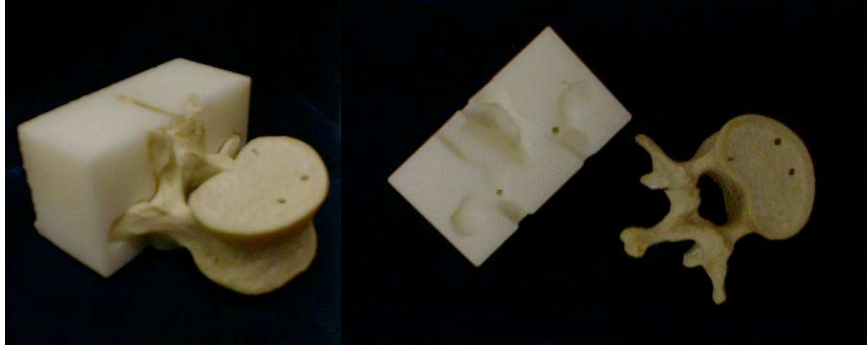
Patient specific 3D printed template for pedicle screw insertion. Template incorporates drill trajectories planned on preoperative CT (courtesy Dr. Terry S. Yoo, National Institutes of Health, USA).
